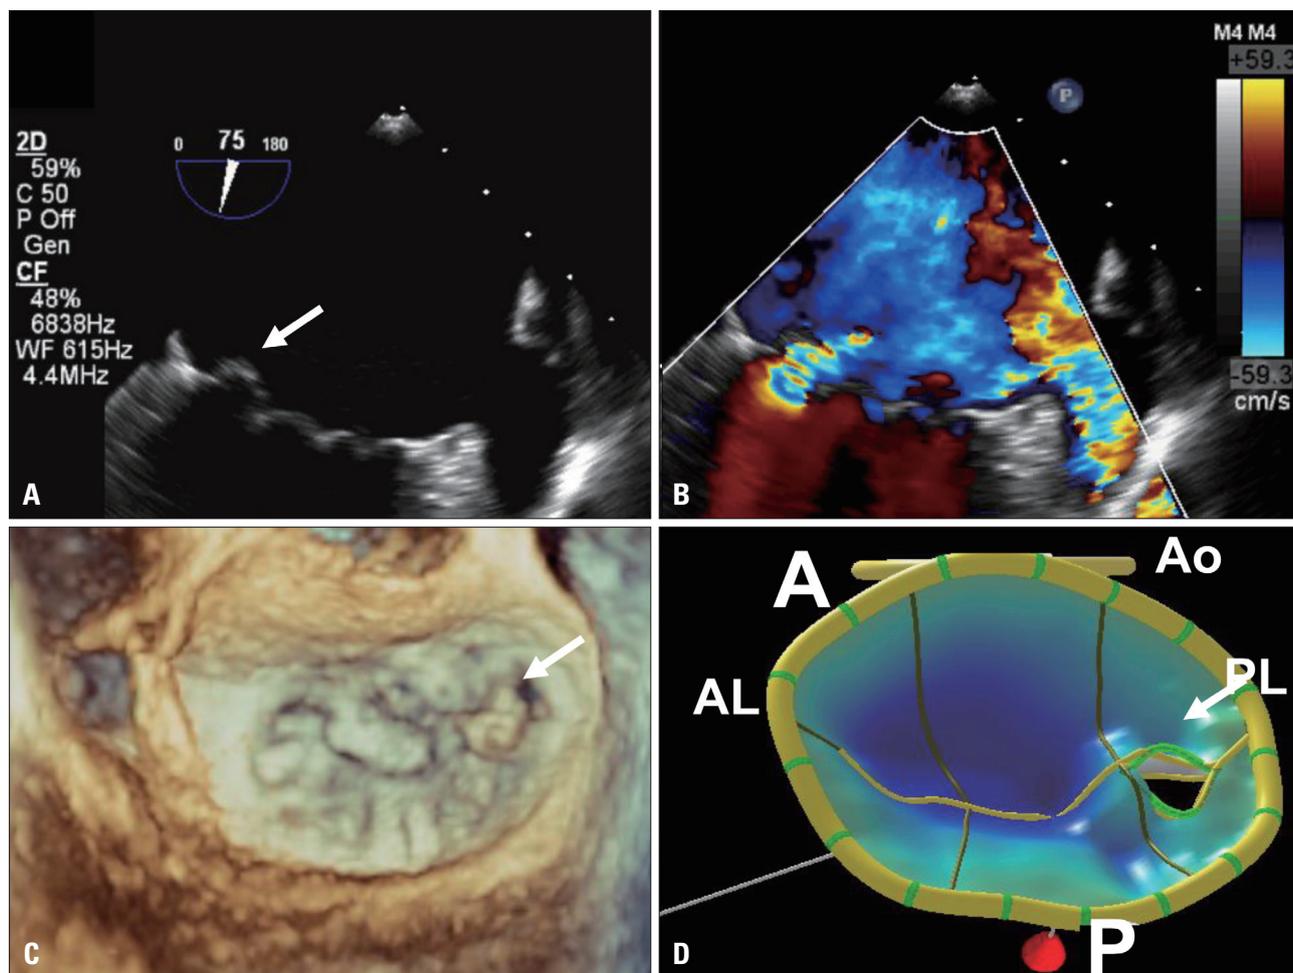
A and B: Multiplane 2-dimensional transesophageal echocardiogram showing commissural view without (A) and with (B) color Doppler. A: From left to right three scallops of the mitral valve are evident postero-medial commissural scallop (arrow), middle segment of anterior leaflet (A2) and lateral segment of posterior leaflet (P1). B: Mitral regurgitation with eccentric jet from the postero-medial commissure direct toward the left appendage. C and D: Real time 3-dimensional (3-D) transesophageal echocardiography. C: Left atrial view (“en face” surgical view) in zoom 3-D acquisition of the mitral valve. The prolapse of postero-medial commissural scallop is evident (arrow). D: 3-D transesophageal echocardiography reconstruction of the mitral valve using the mitral valve quantification software. A defect of mitral valve coaptation is present the level of the postero-medial commissure.
